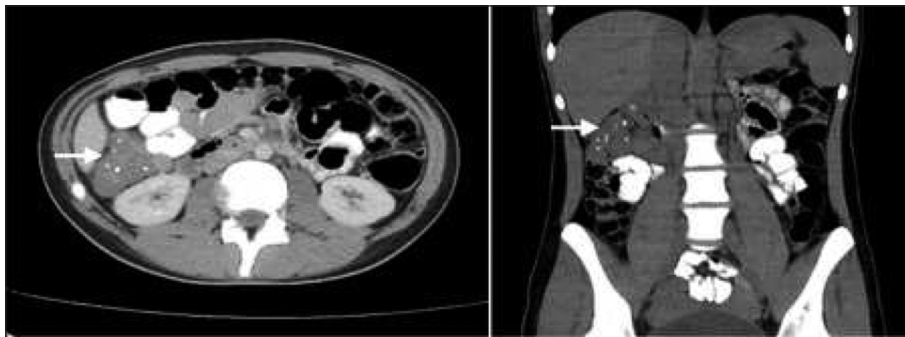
In abdominal CT, a solid mass 4x5 cm in size with dot-style calcifications, which is located between liver and right kidney on hepatic flexura (arrow).
